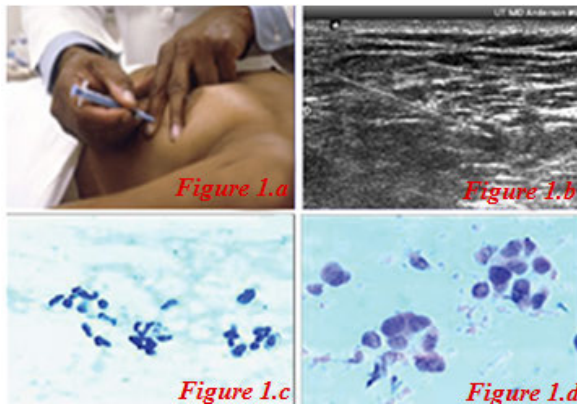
FNA Test and Samples, Figure 1 a. Biopsy, Figure 1 b By Ultrasound, Figure 1 c. Benign Sample, Figure 1 d. Malignant Sample
